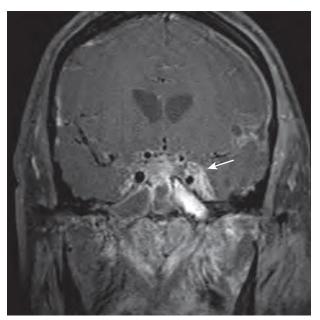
Magnetic resonance image of cavernous sinus thrombosis. Arrow points to contrast-enhanced cavernous sinus with a dark circle of a flowing carotid artery (flow void signal). The dark white area below is the inflamed sphenoid sinusitis, which caused the cavernous sinus thrombosis.
